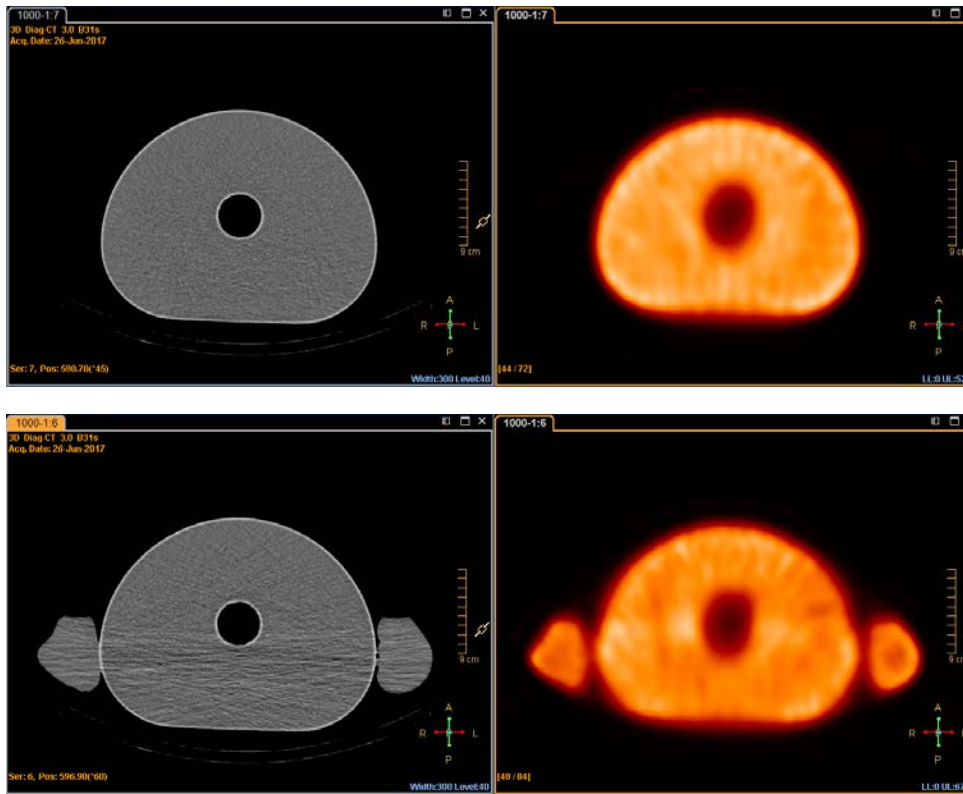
CT scan of 80 kV and 100 mAs, artefacts are still visible in the CT images with the arms down. Owing to the soft filter applied to CT before the calculation of CTAC, the streaks do not propagate into the SPECT image, but quantitation is affected.
